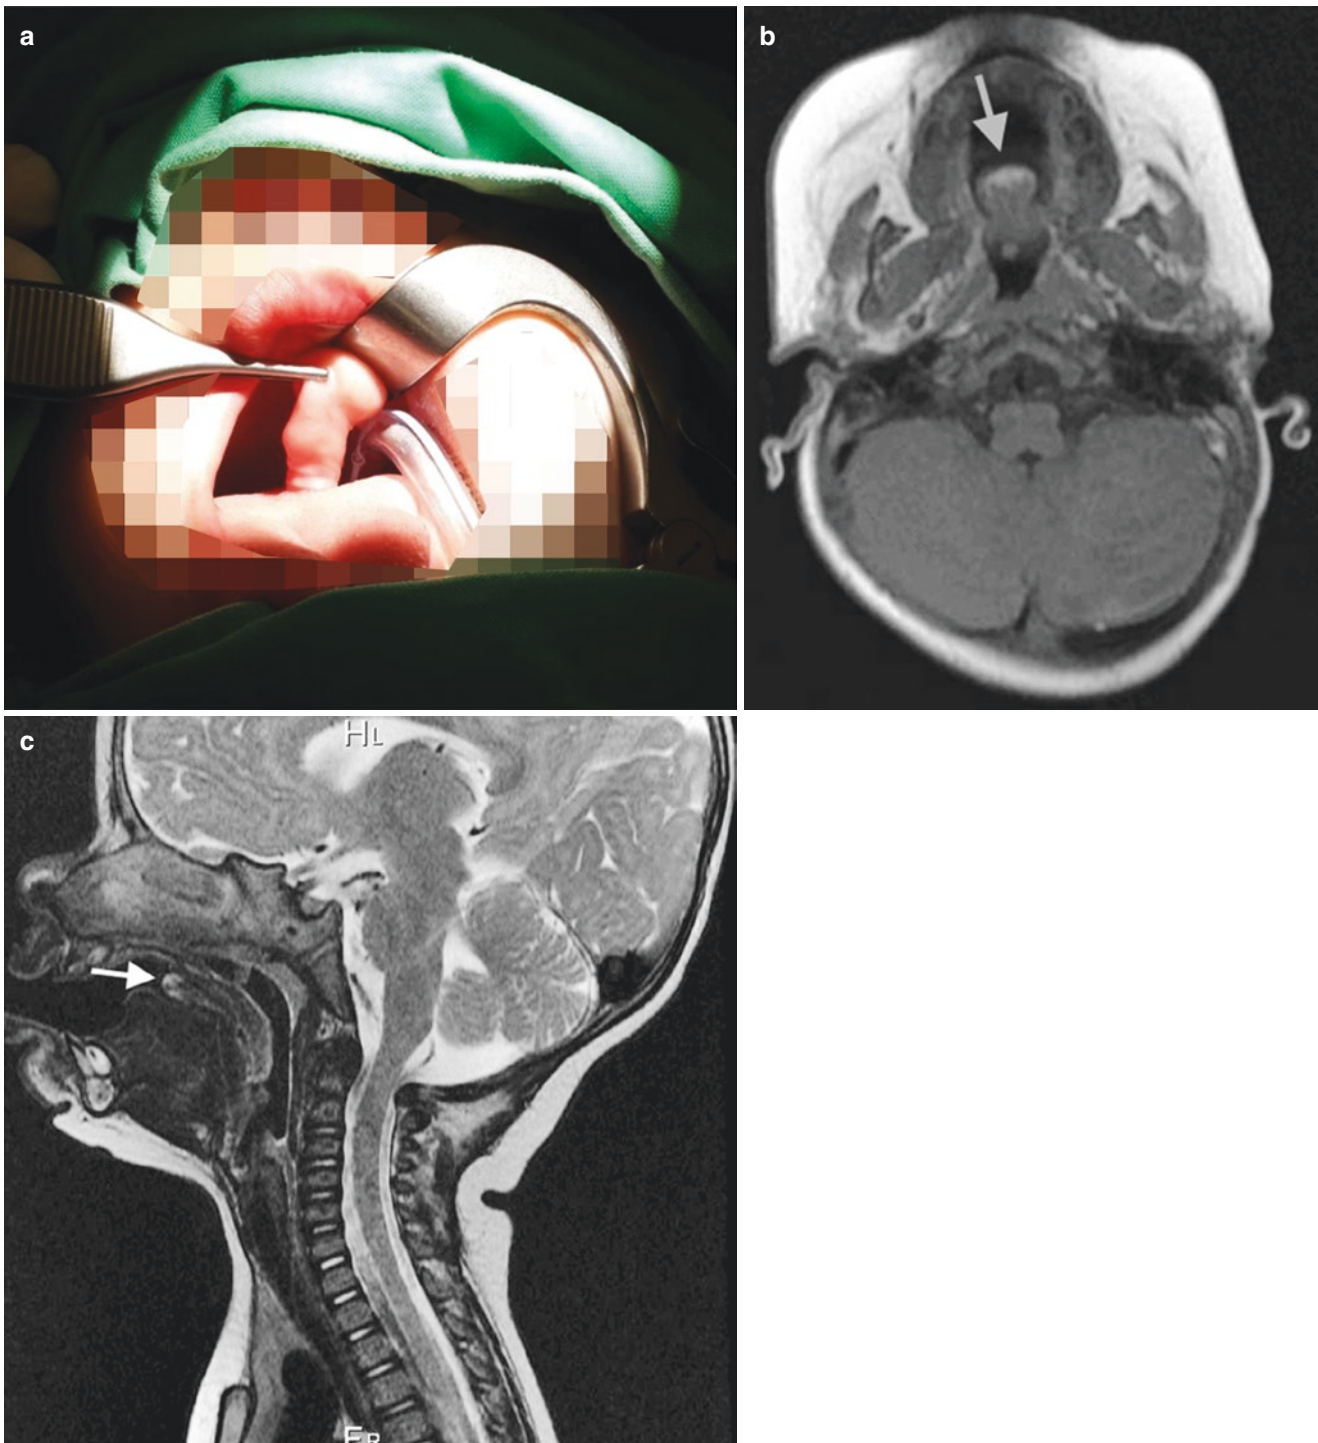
(a) Well epithelialized polypoid mass from tongue. (b) Axial T1 MRI shows “polypoid” tongue mass (arrow) to be isointense to the normal tongue base tissue. (c) Sagittal T2 MRI showing no change in intensity of the mass from the T1 image in the previous figure
